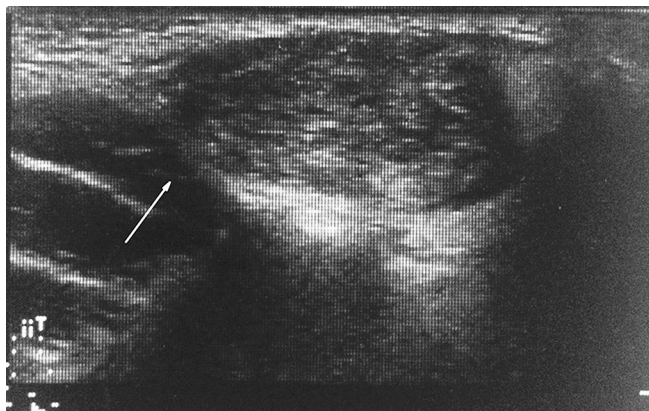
Ultrasonographic showed a weak echo mass, measuring 2.0 cm in diameter, located below the in upper superficial lobe of the left parotid gland. The mass had a well-defined margin (white arrow)
